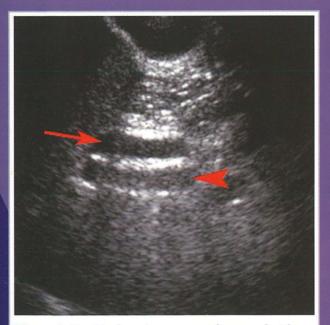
Double duct sign seen on ultrasound with a dilated common bile duct (arrow) lying anterior to the portal vein (arrowhead).
